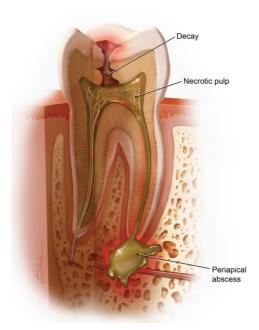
Periapical Abscess⁷
